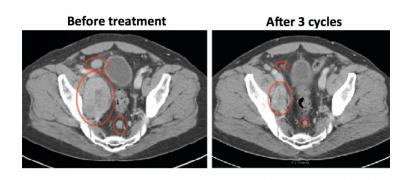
show hormonal therapy, these abdominal CT scans of a man with prostate cancer show that injections of testosterone reduced the size of metastatic tumors (red circles). (http://www.sciencemag.org/news/2015/01/cancer-paradox-testosterone-injections-combat-lethal-prostate-tumors)
